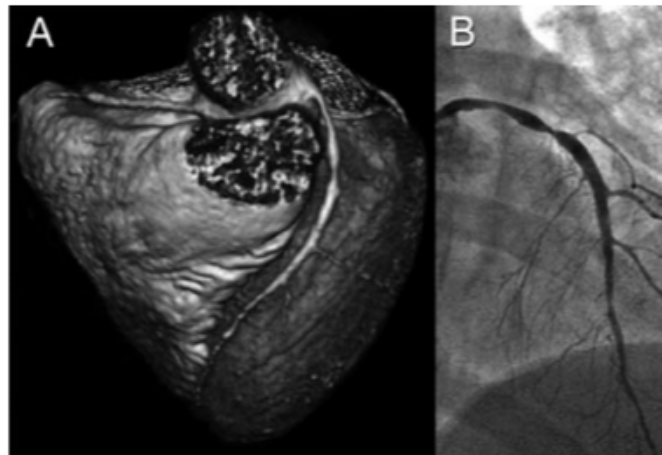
Example of significant stenosis of the left anterior descending coronary artery from focal non calcific atherosclerosis with coronary computed tomographic angiography(A) and invasive coronary angiography (B). Figure adapted from [5].
